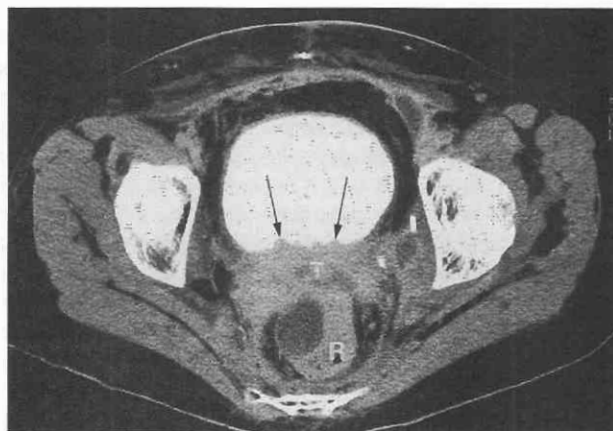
Recurrent cervical cancer. CT scan shows a central pelvic tumor (T) after hysterectomy involving the anterior rectum (R) and posterior bladder wall (*arrows*) and extending to both pelvic sidewalls on this delayed excretory-phase image. Note the lymphadenectomy clip in the left obturator fossa.
